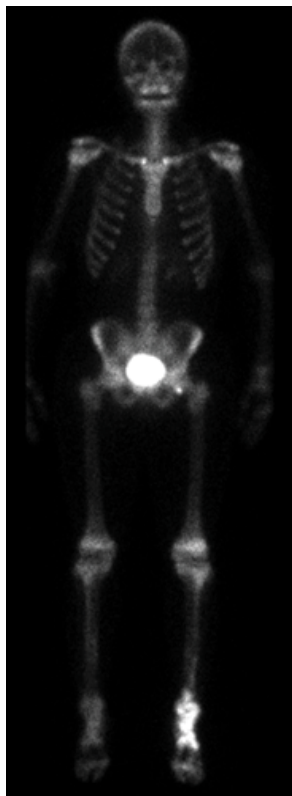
Whole-body ^{99m}Tc-MDP bone scintigraphy. Anterior and posterior projections demonstrate multifocal increased radiotracer uptake involving the distal left tibia, ankle, and multiple bones of the foot. No abnormal radiotracer uptake is identified elsewhere in the appendicular or axial skeleton.
